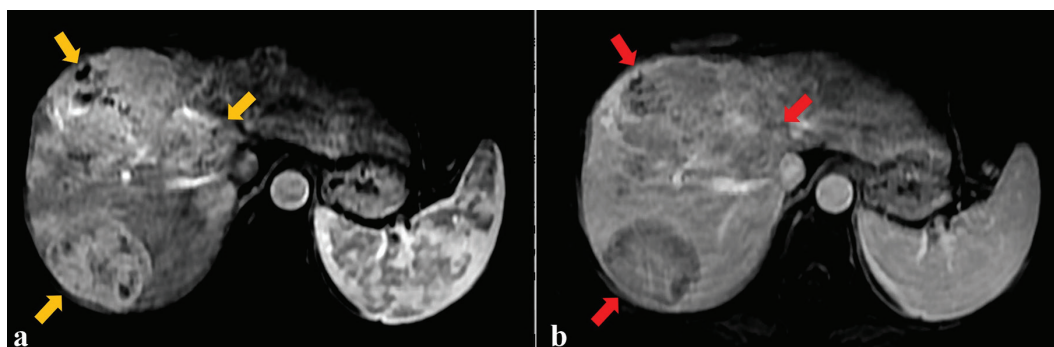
Abdominal MRI images: (a) axial T1-weighted arterial phase image; (b) axial T1-weighted portal venous phase image. Hepatomegaly with cirrhotic changes related to multiple hypointense focal lesions, in pre contrast image with hyperenhancement in the arterial phase (yellow arrows) and washout on the portal venous phase with capsular enhancement (red arrows).
